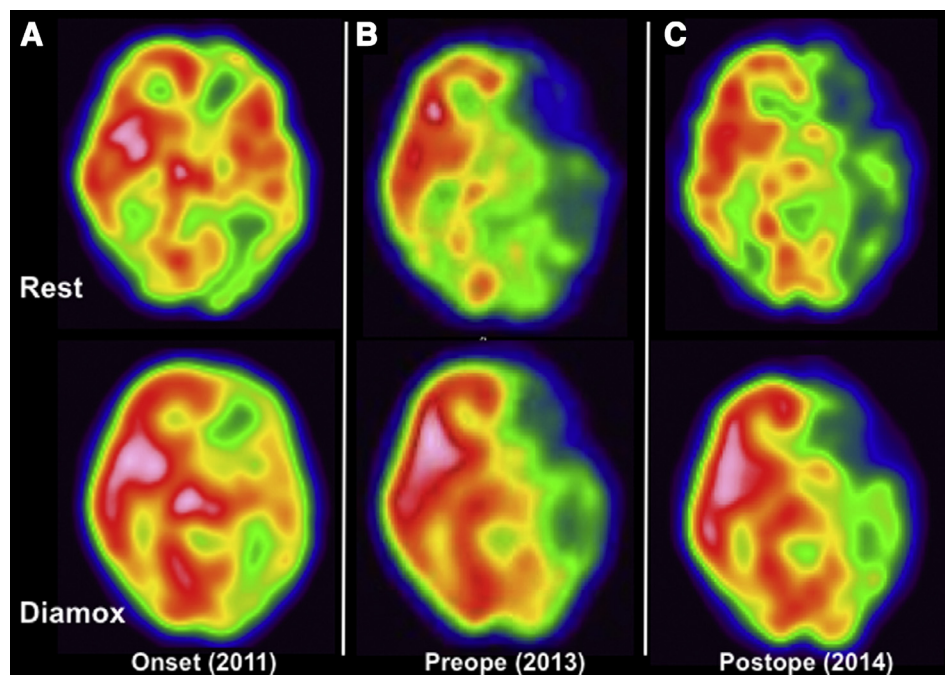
^{123}I -IMP-SPECT studies at onset in 2011 (A); at preoperative state in 2013 (B); and 1 year after indirect revascularization in 2014 (C). Resting studies are shown in the upper row, and acetazolamide-stress studies are shown in the lower row. Progressive severely impaired CBF and CVR were found 2 years after onset, and were not improved after indirect revascularization. Abbreviations: ^{123}I -IMP-SPECT, [^{123}I] iodoamphetamine single-photon emission computed tomography; CBF, cerebral blood flow; CVR, cerebrovascular reactivity.
